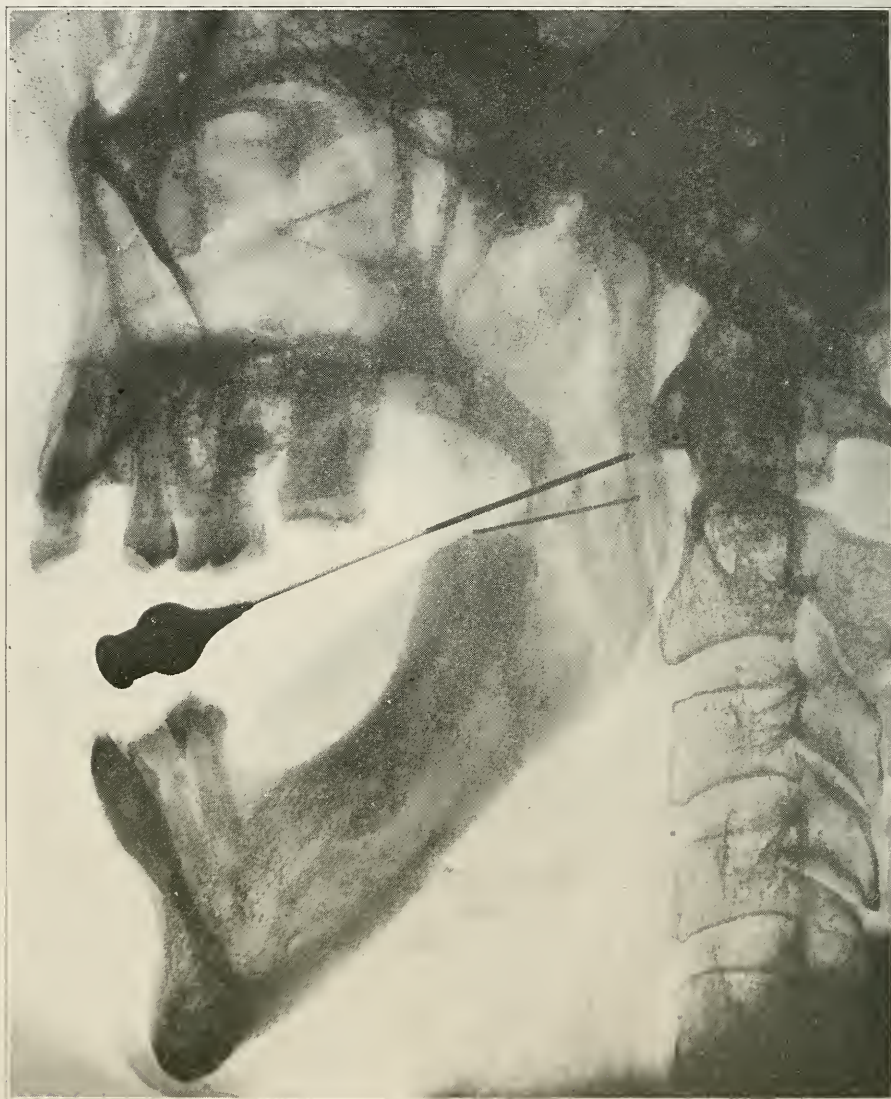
X-ray of right lower jaw showing broken needle medial to ascending ramus in region of inferior dental lingual nerves. Note the inferior position of broken fragment to second needle. Lateral exposure. (See Fig. 568.)
